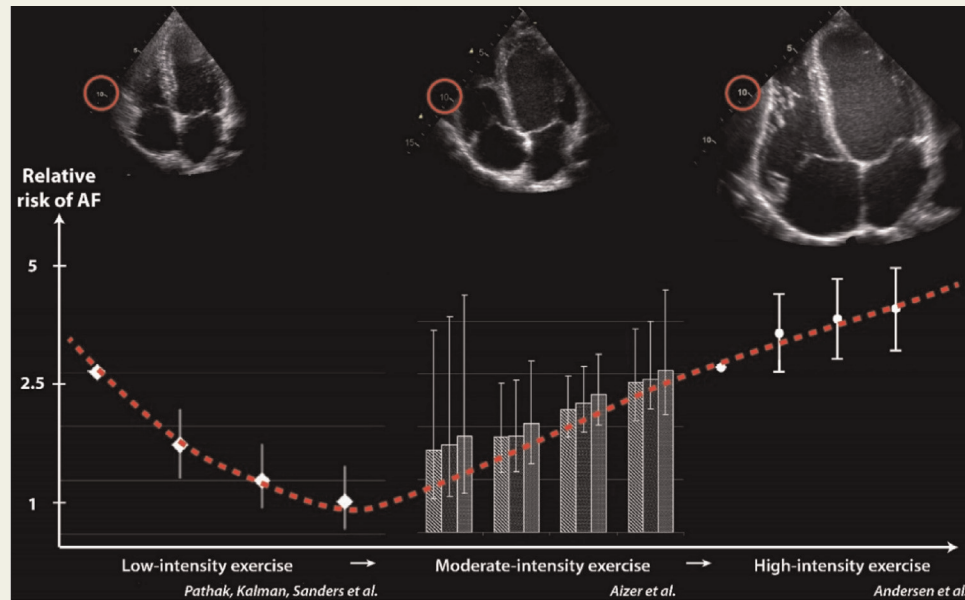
J-shaped relationship between exercise dose and the relative risk of developing AF. The echocardiograms are represented at relative scale (10 cm marker highlighted) demonstrating the increase in heart and atrial size with training (Reproduced with permission. La Gerche et al. *Eur Heart J* 2013).
